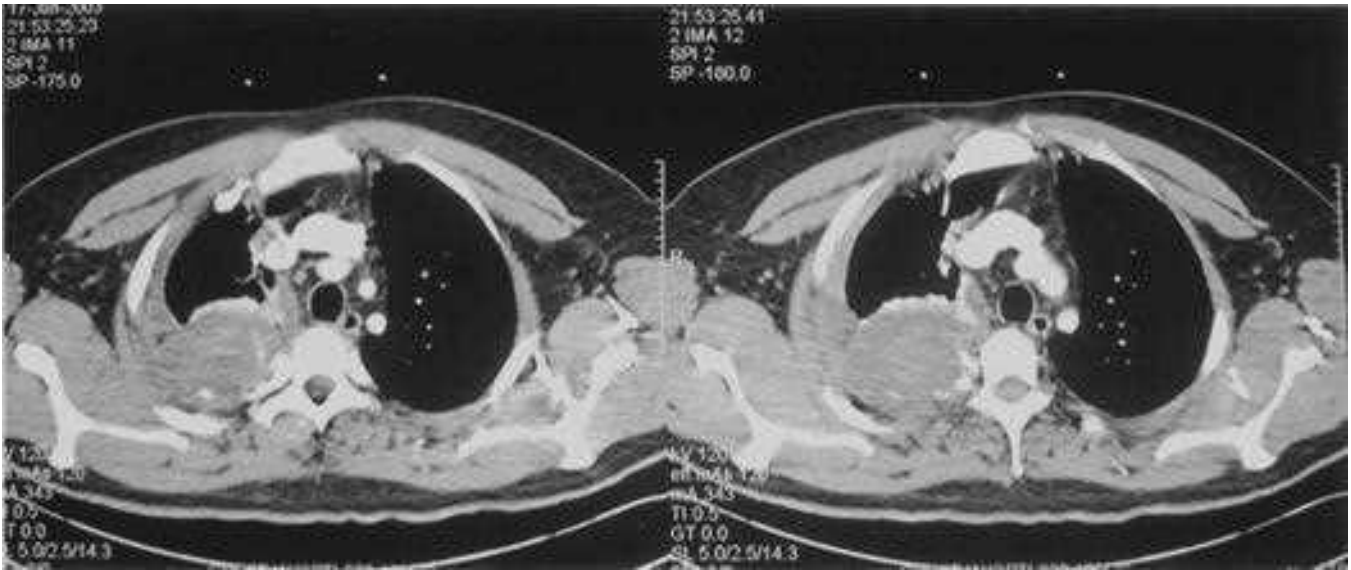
Chest computed tomography scan showing a right posterior lung tumor. In the appropriate clinical setting, stippled calcifications (white streaks in right lung mass) are highly indicative of chondrosarcomas.
